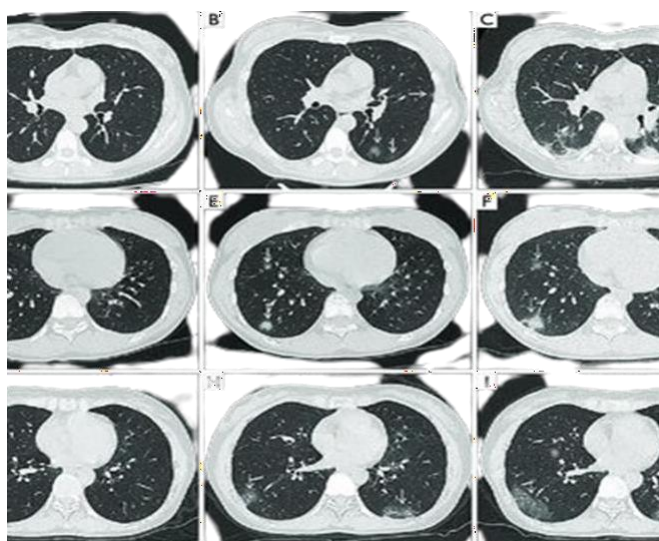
CT lung cancer images (Kareem et al 2021).
